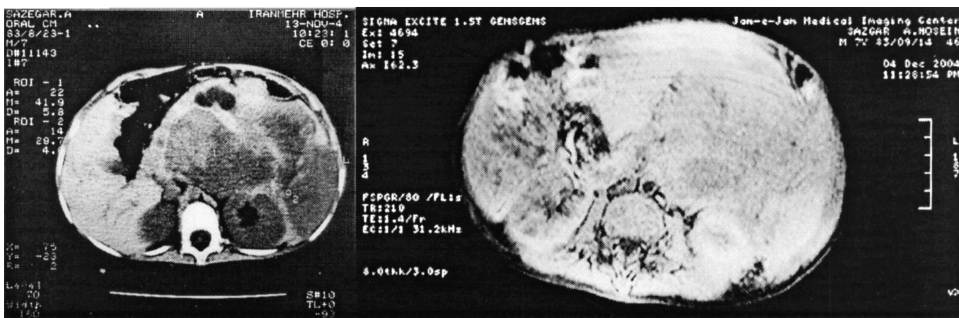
Abdominal CT scan and MRI, 9 months after chemotherapy.
